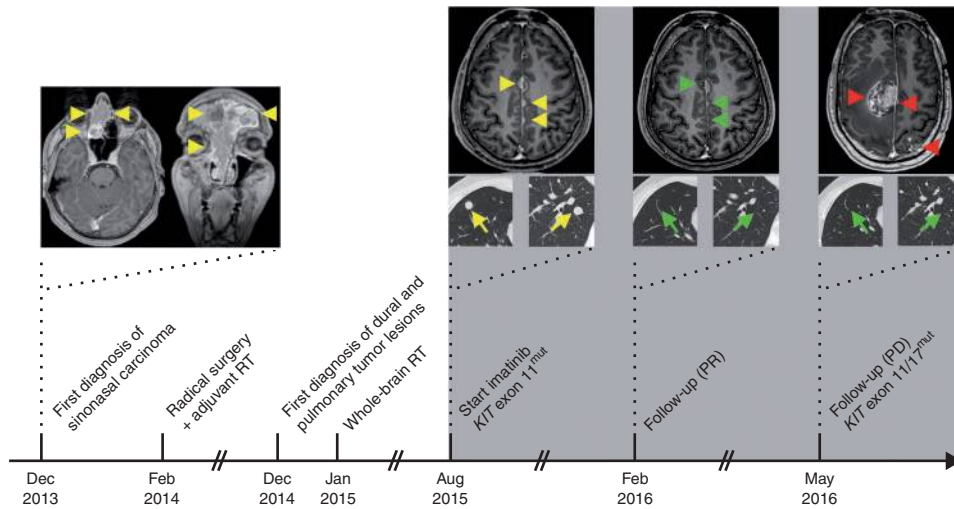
Course of disease. Left, axial and coronal contrast-enhanced, T1-weighted MR images of the brain depict the extent of the primary tumor. Middle and right, axial contrast-enhanced, T1-weighted MR images of the brain show response of nodular dural metastases to therapy (top); axial contrast-enhanced computed tomography (CT) images of the lung demonstrate response of pulmonary nodules to therapy (bottom). Arrows and arrowheads indicate actual or former tumor localizations. Yellow, lesions before imatinib treatment; green, responsive lesions; red, progressive lesions. RT, radiotherapy; PR, partial remission; PD, progressive disease.
